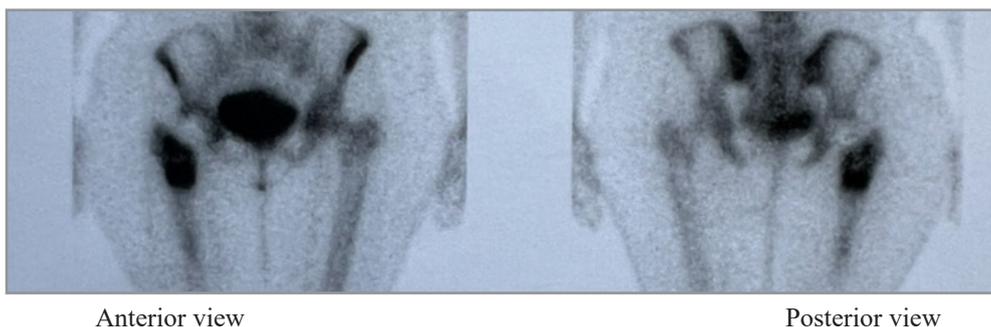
Three-phase bone scintigraphy demonstrating intense periprosthetic metabolic uptake involving the femoral stem of the right hip prosthesis.
